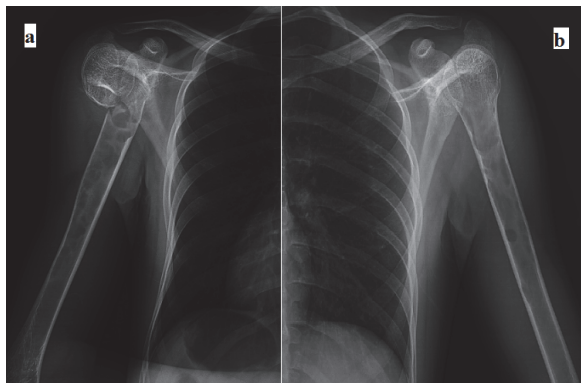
Patient preoperative plain radiographs humerus. Left pathologic humeral shaft fracture and extending cystic lesions(1a), the right humeral metaphyseal-diaphyseal complete multiple cystic lesions, hypodense areas(1b).
